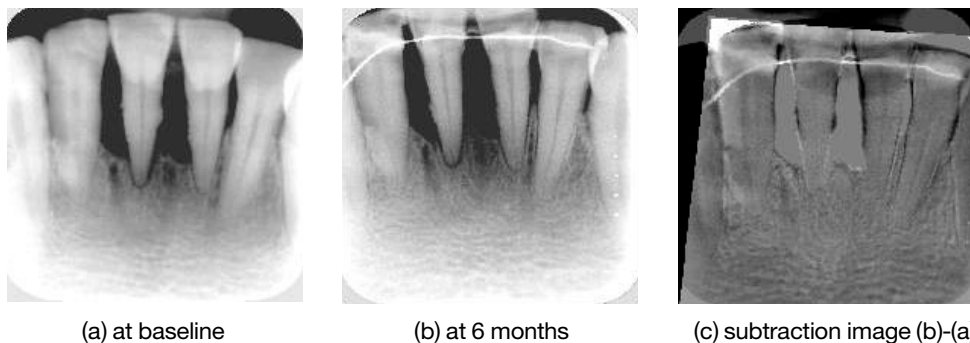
Example of digital subtraction radiography
